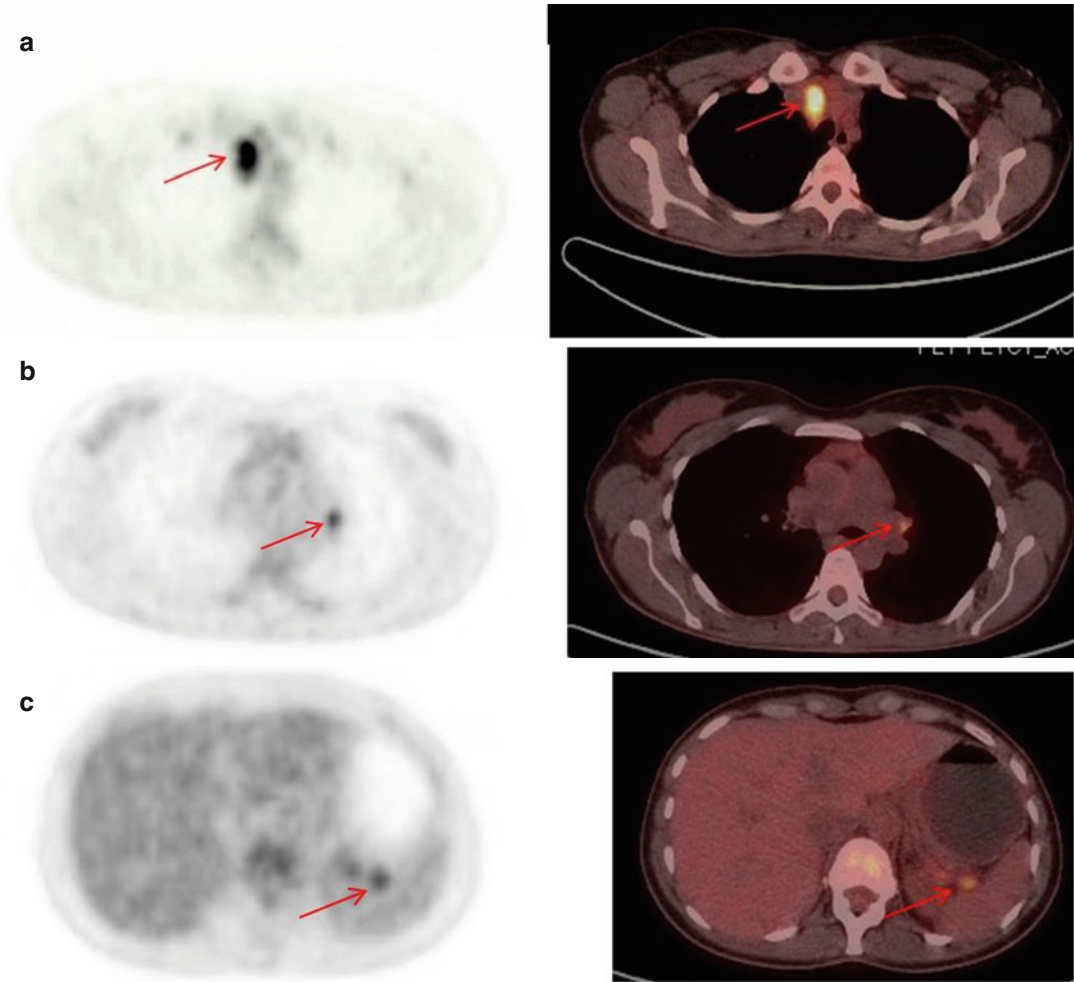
(a–d) PET/CT staging. Hypermetabolic lesions at the anterior mediastinum (a), left hilar lymph node (b), splenic hilar nodes (c), T11 vertebra (d)
